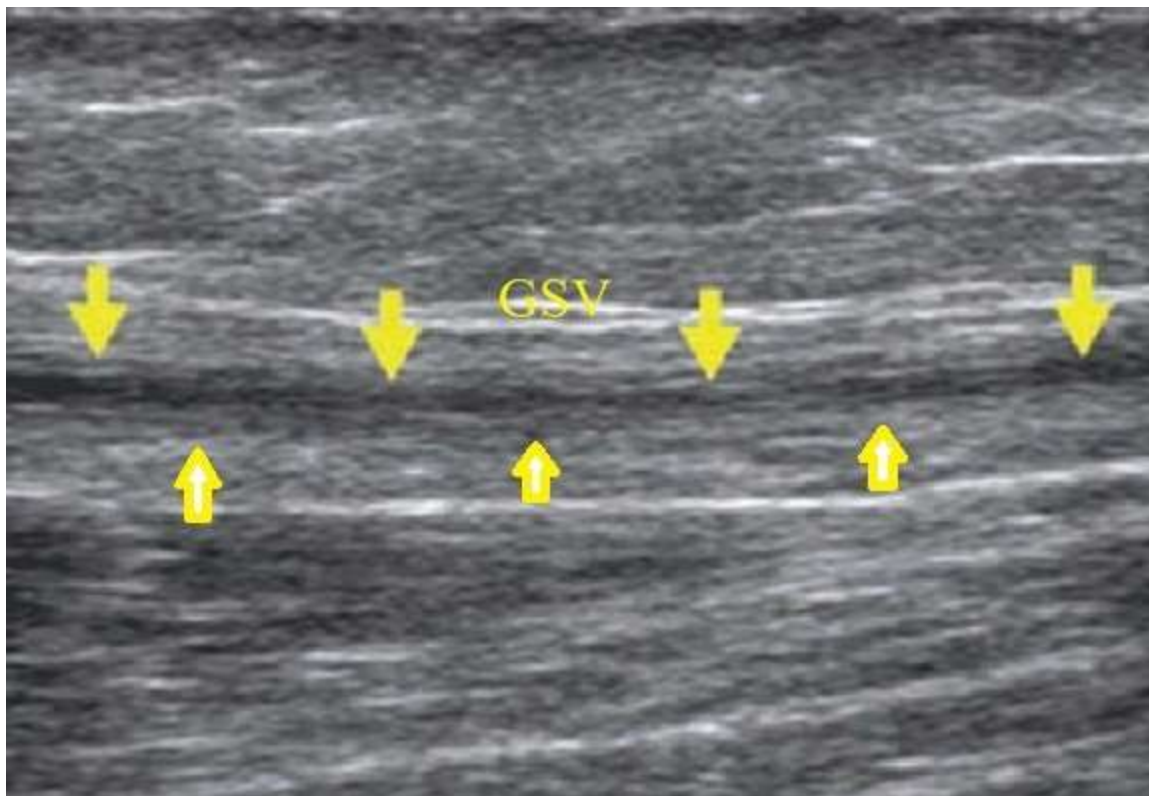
Ultrasound done after 6 months follow up revealed significant reduction in the size of the GSV.
